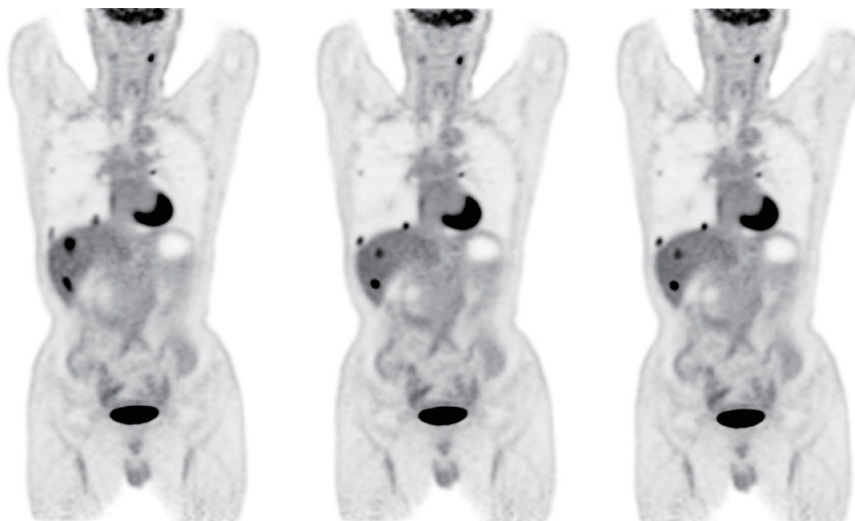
Coronal views of 2- ^{18}F]FDG PET images for a 57-year-old man with pheochromocytoma. Two lesions in the right lower lung and 2 in the liver can be appreciated in NMC (left). The lung lesion in the costophrenic angle and the lesion in the lower liver lobe were considered to have severe and mild motion artifacts, respectively. After motion corrections, improvements were observed in all 4 lesions in VSMC and DDGMC (middle and right). The diaphragm motion was rated as none or minor in all reconstructions. The raters considered the image quality of VSMC and DDGMC to be equal. 2- ^{18}F]FDG, 2-deoxy-2- ^{18}F]fluoro-D-glucose; PET, positron emission tomography; NMC, no motion correction; VSMC, vital signal module-based motion correction; DDGMC, data-driven gating-based motion correction.
